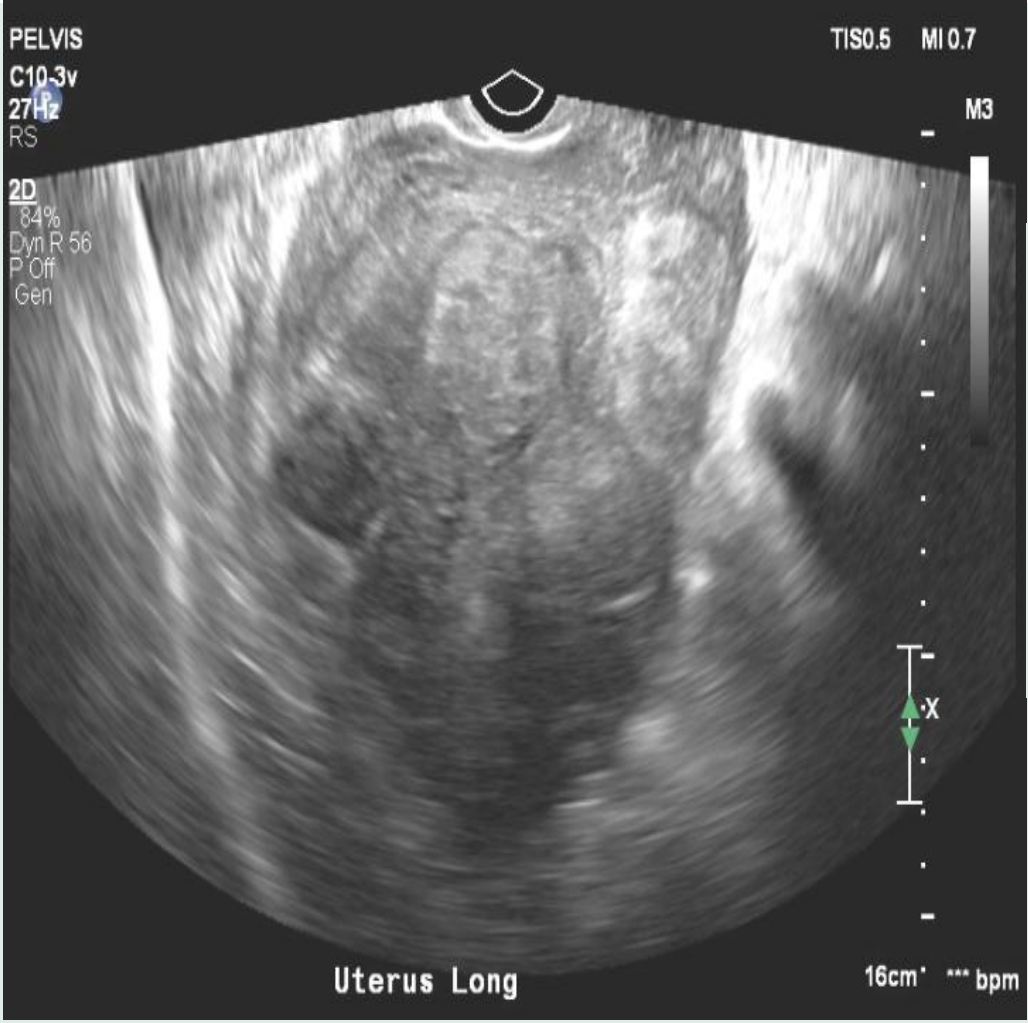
Longitudinal view of the uterus on transvaginal ultrasound
